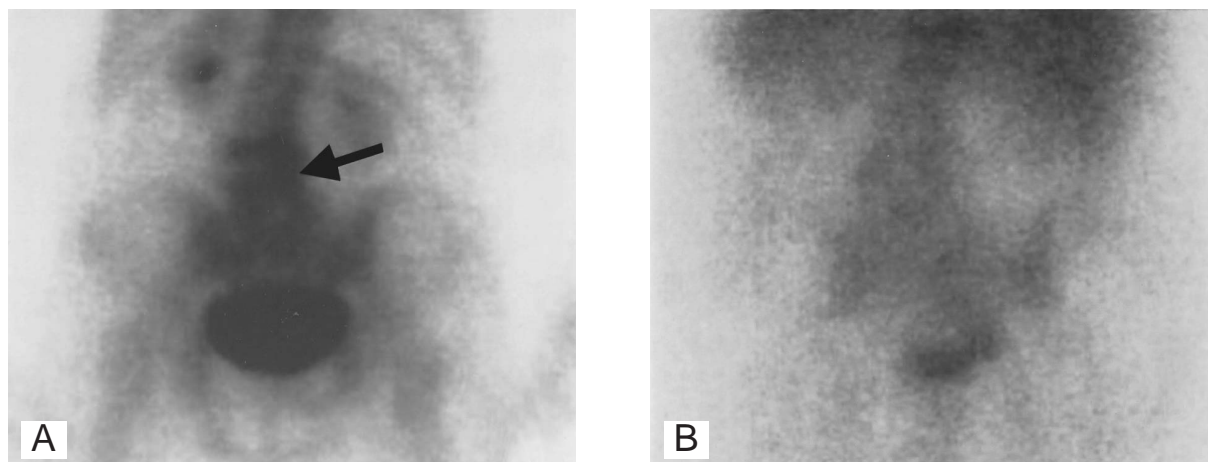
the Tc-99m MDP bone scan showed abnormally increased radioactivity in the L3/4 levels. B: No abnormal uptake was noted on Ga-67 scintigraphy.
